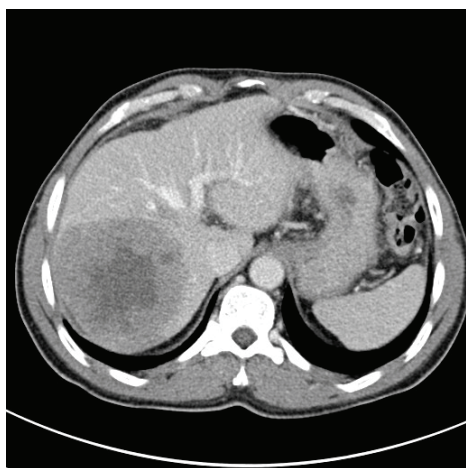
The patient with hepatocellular carcinoma before the portal vein embolization. Computed tomography scan shows a large hypodense and heterogenous tumor in the segments VII and VIII and partially in the segments V and VI of the right hepatic lobe, measuring 88 × 90 × 90 mm, with necrosis in the central part.
